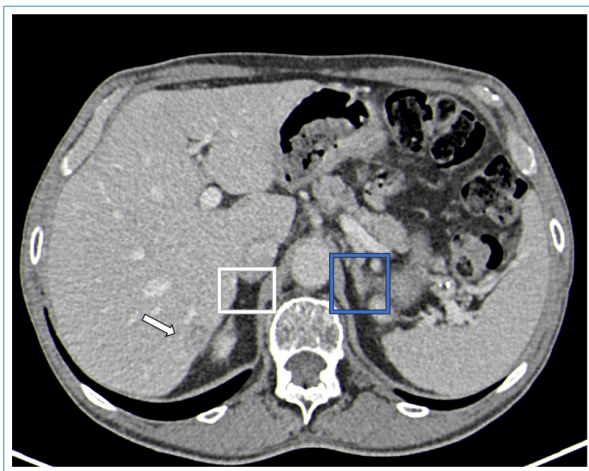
Computed tomography scan, axial portal phase. The white arrow shows washout; white square shows where the right adrenal gland was supposed to be observed; the blue square shows the left adrenal gland.
